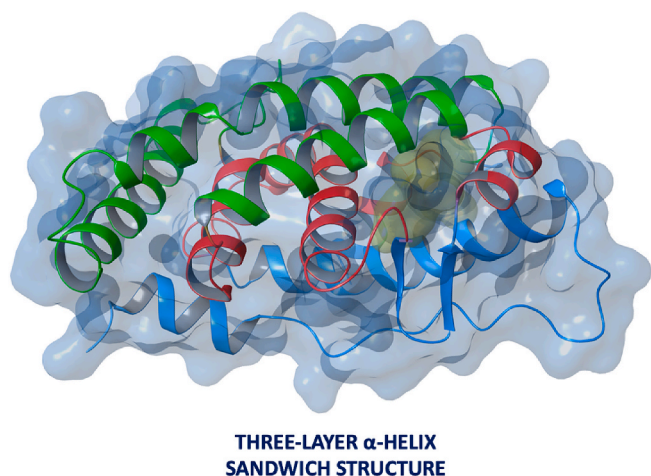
X-Ray structure of three-layer α -helix sandwich structure of ER ligand binding pocket (PDB ID: 2EWP) [28].
